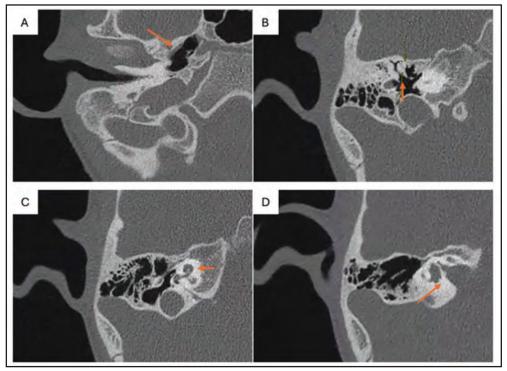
HRCT temporal bone images (bone window) in axial view, showing the abnormalities (Orange coloured arrows). A; right patulous eustachian tube, B; malformed incus and malleus and fixed in the attic, C; hypoplastic apical turns of cochlear (1.5 spiral turns), D; funnel-shaped internal auditory meatus
